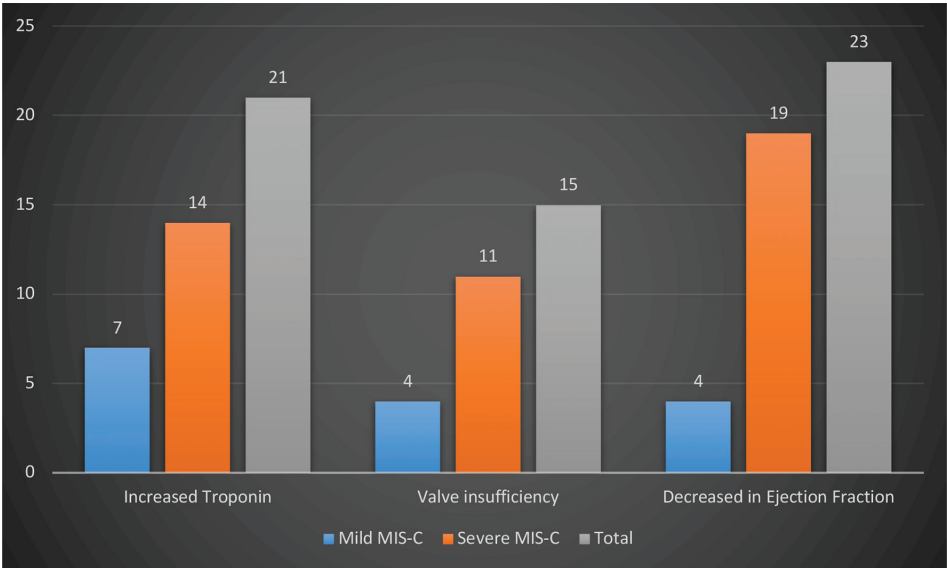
Significant cardiac markers and echocardiographic findings
